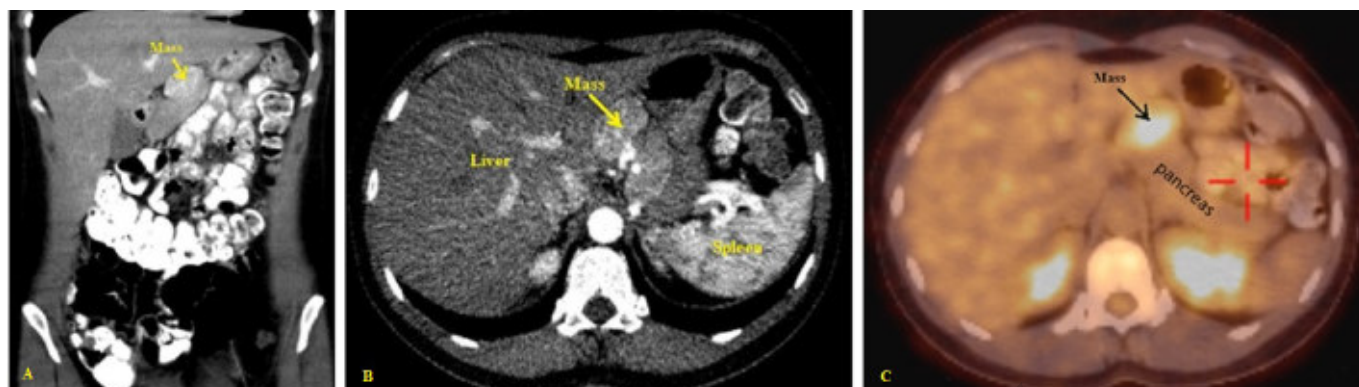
Preoperative imaging of Castleman's disease. Coronal (A) and axial (B) images in abdomen CT shows well-defined mass and consistent with Castleman's disease (arrow). FDG PET-CT revealed increased FDG uptake (SUV-max:6.1) located exophytically in the antero-superior border of pancreas body (arrow).
